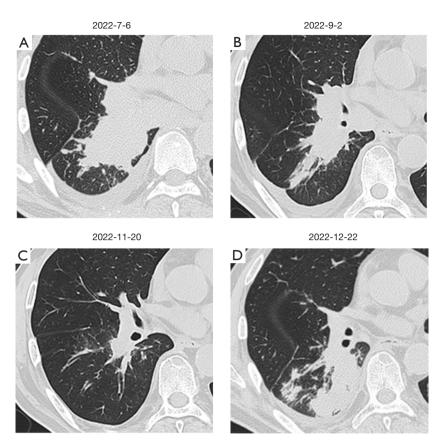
Chest computed tomography images. (A) Computed tomography images at baseline before treatment, (B) after two cycles of therapy, (C) after five cycles of therapy showing partial response, and (D) 1 month after showing progressive disease.
